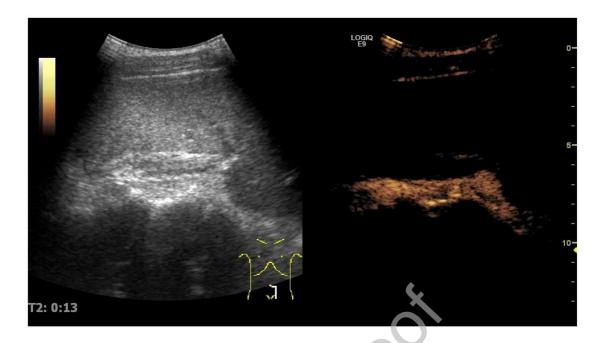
Contrast- enhanced ultrasound (CEUS) images of an infarction in a wandering spleen. CEUS revealed that the spleen was located in the pelvic cavity.
